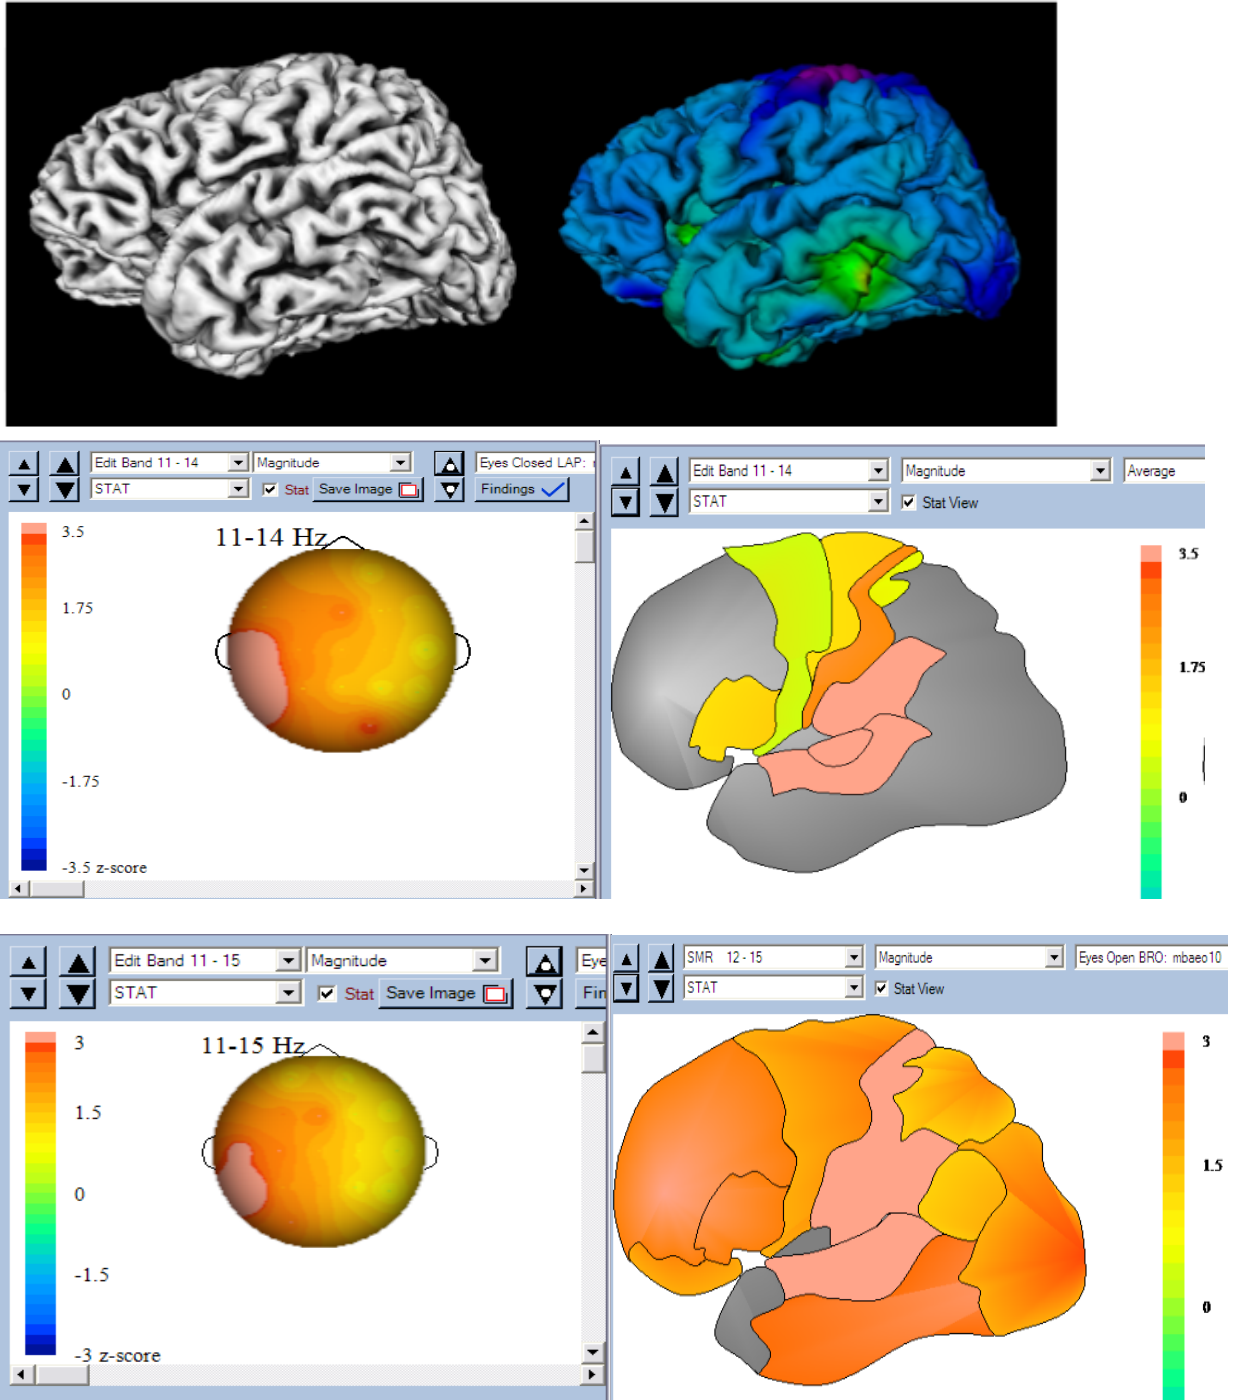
Collage of images comparing PET and MRI findings (top) with statistical findings using QEEG brain map and Brodmann Area evaluations of 11-15 Hz activity during eyes closes (mid) and eyes open (bottom) states. Findings are comparable in identifying same abnormal region in left temporal lobe. However, disruption of parietal areas is greater with eyes open.
